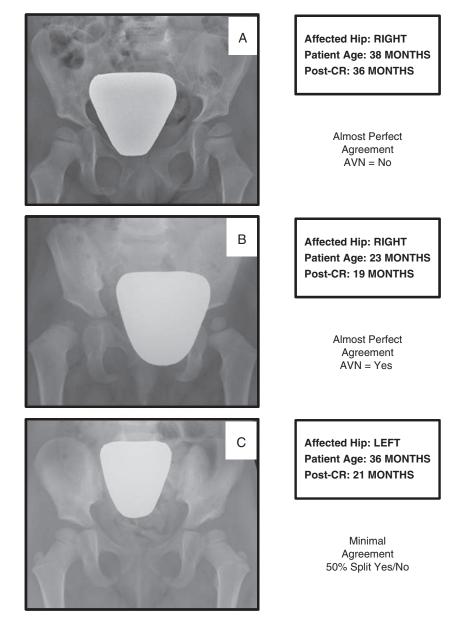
Example cases—levels of agreement between surgeons. In these examples, there was near perfect agreement between surgeons to the presence (A) or absence (B) of AVN in these children. In some radiographs, there was minimal agreement between surgeons, with 50% of surgeons answering yes and 50% answering no (C). AVN indicates avascular necrosis; CR, closed reduction.
